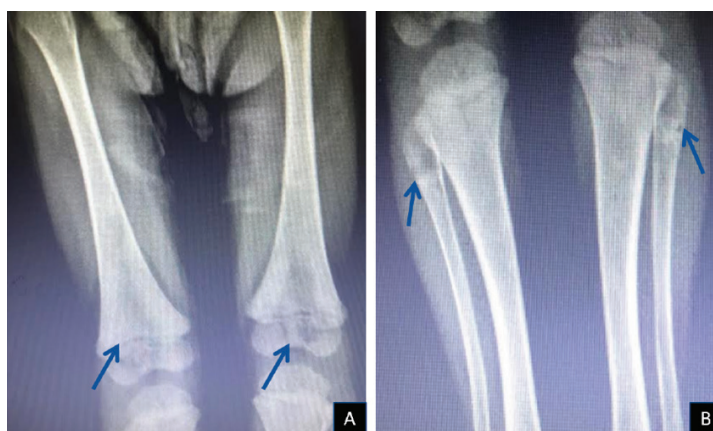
X-ray images of lower extremities (A, B). A. Characteristic “tongue” sign of metaphyseal radiolucencies are present in the femoral metaphysis (arrows). B. Oval radiolucent lesions and apparent physal widening are present in the proximal fibula (arrows)
